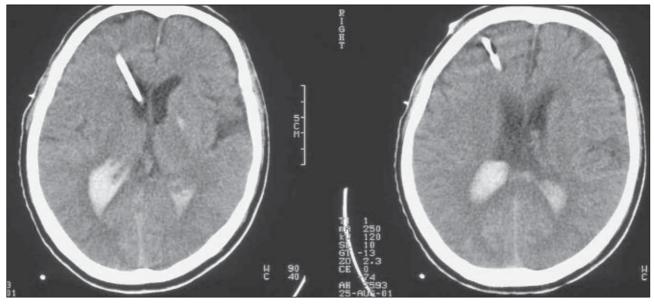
Computed tomography scans showing the third and fourth ventricles are cleared of blood
